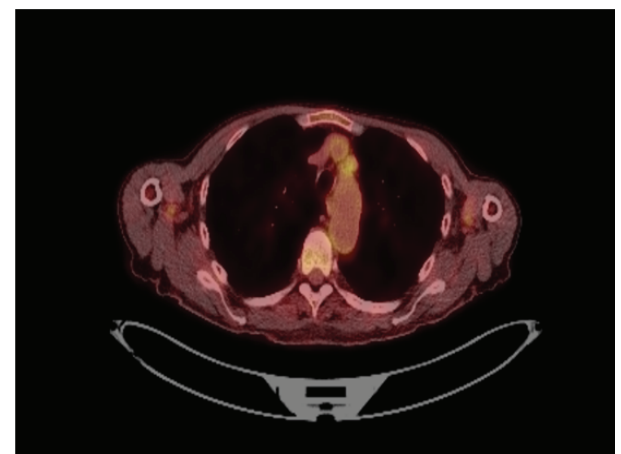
CT-PET image showing increased uptake of tracer (F-18 FDG) in the aortic arch of patient two
